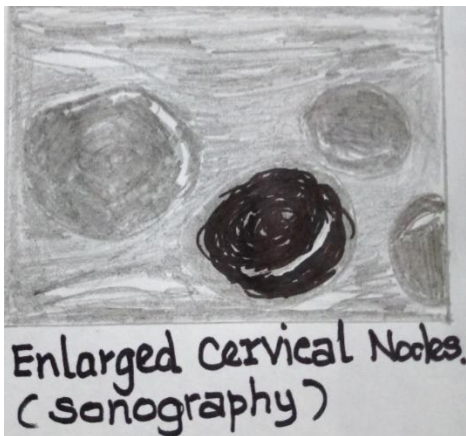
Ultrasound image of cervical lymph nodes
